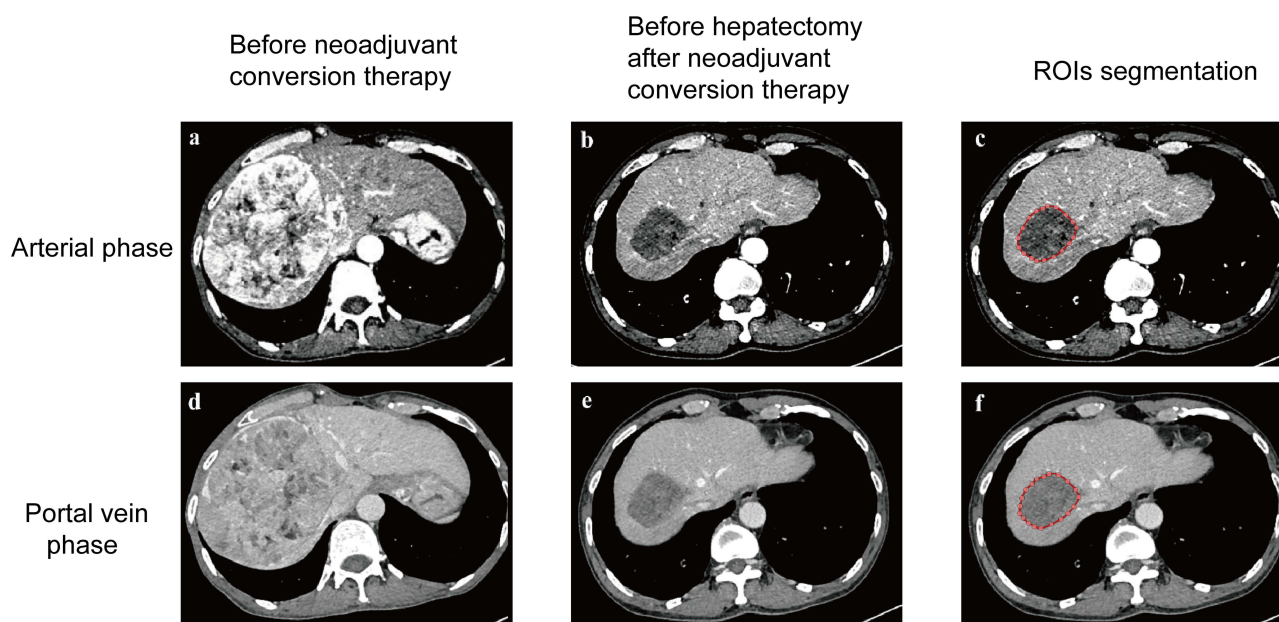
Representative contrast-enhanced CT images of an initially unresectable hepatocellular carcinoma patient with pathological complete response following by neoadjuvant conversion therapy. Arterial phase (a) and portal vein phase image (d) before neoadjuvant conversion therapy. Preoperative arterial phase (b) and portal vein phase image (e) after neoadjuvant conversion therapy. Hand-plotted ROI from preoperative arterial phase (c) and portal vein phase image (f) after neoadjuvant conversion therapy.
